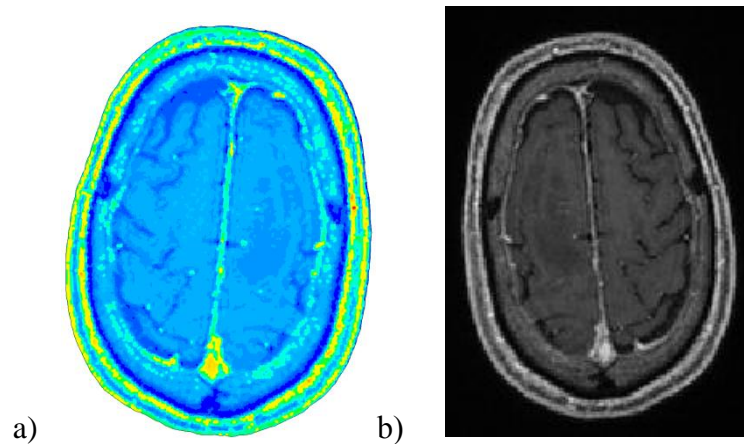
a) Mass density distribution; b) Sample CT slice
